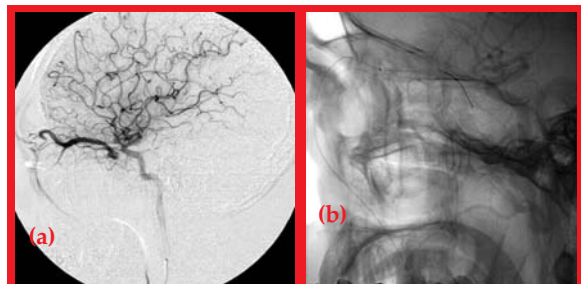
(a) Angiogram, lateral view, showing a dural CCF anterior to the internal carotid artery with venous drainage into superior ophthalmic vein. (b) Skull X-ray, lateral view, showing the passage of the microcatheter via the facial vein into the superior ophthalmic vein. (c) Post-embolisation angiogram, lateral view, showing complete occlusion of the dural CCF with coils.
